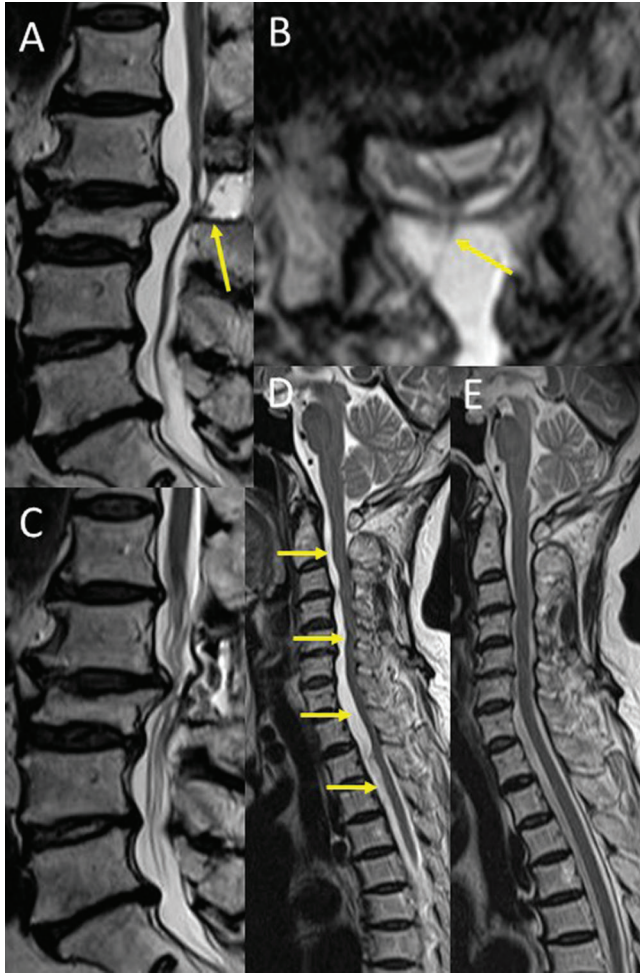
Preoperative and post-2nd operative MRI of lumbar spine. (A, B) Herniated cauda equina fibers at L2-3 level (yellow arrows). (D) SSEH extending from lumbar spine to the cranium (yellow arrows). (C, E) Lumbar MRI after the post-2nd operation demonstrating disappeared SSEH. The displaced spinal cord returned to its original position. MRI: magnetic resonance imaging, SSEH: spinal subdural extra-arachnoid hygroma.
